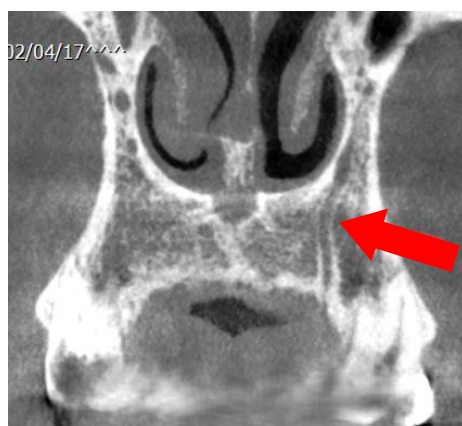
The pathway of the CS canal in the maxillary bone, clearly visible in the coronal section of the CBCT image.
